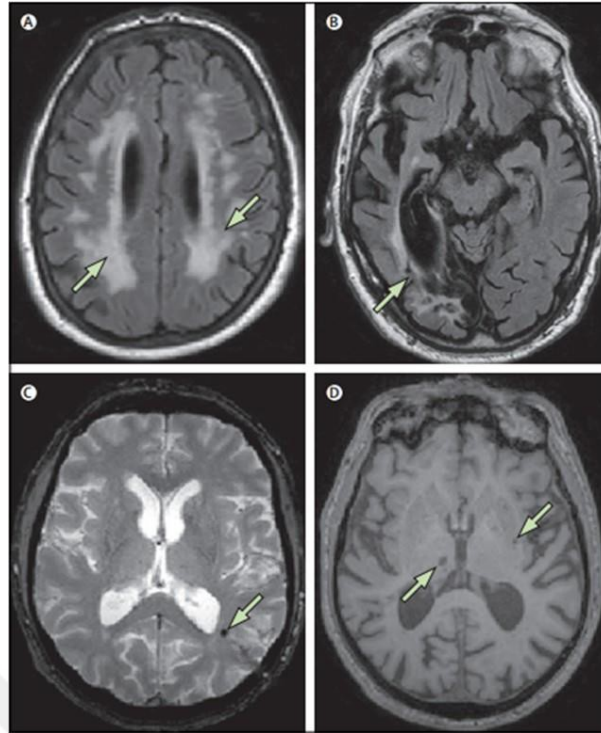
Vascular dementia MRI imaging was demonstrated [19].
